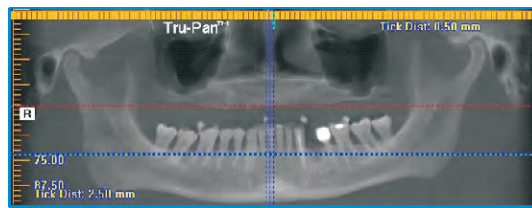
Pre-operative intraoral orthopantomogram with scan denture placed intraorally.
